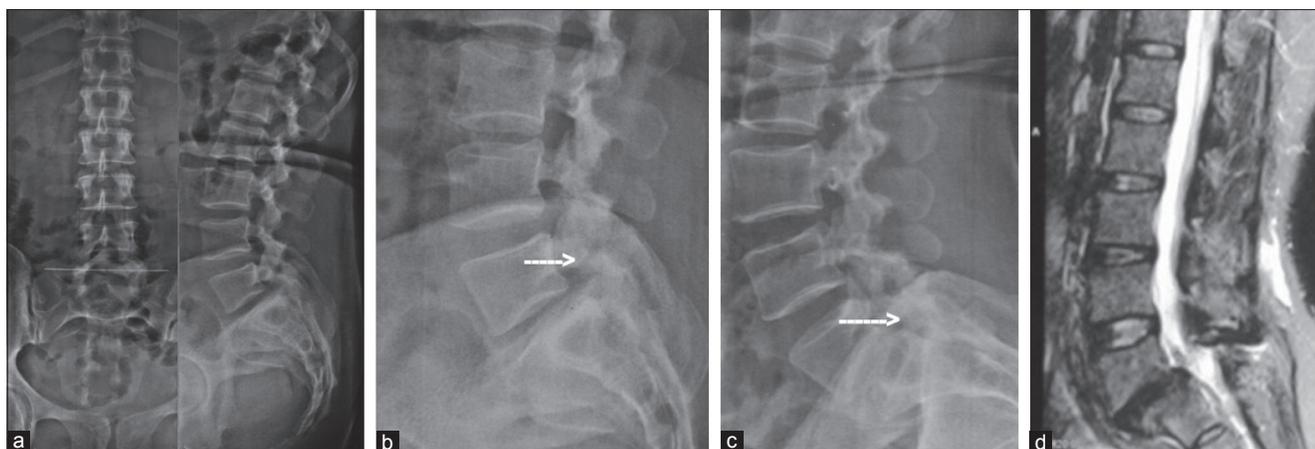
Spondylytic instability managed by TLIF: X-ray lumbosacral spine anteroposterior view (a) and lateral view (b) showing grade-I spondylytic spondylolisthesis instability at L_5/S_1 level. (c) Dynamic lateral view (flexion) showing spondylolysis (arrow) and anterior translation. (d) Dynamic lateral view (extension) showing spondylolysis (arrow) and angular motion at L_5/S_1 level. (e) T2W MRI scan of that patient showing involvement of L_5/S_1 level
